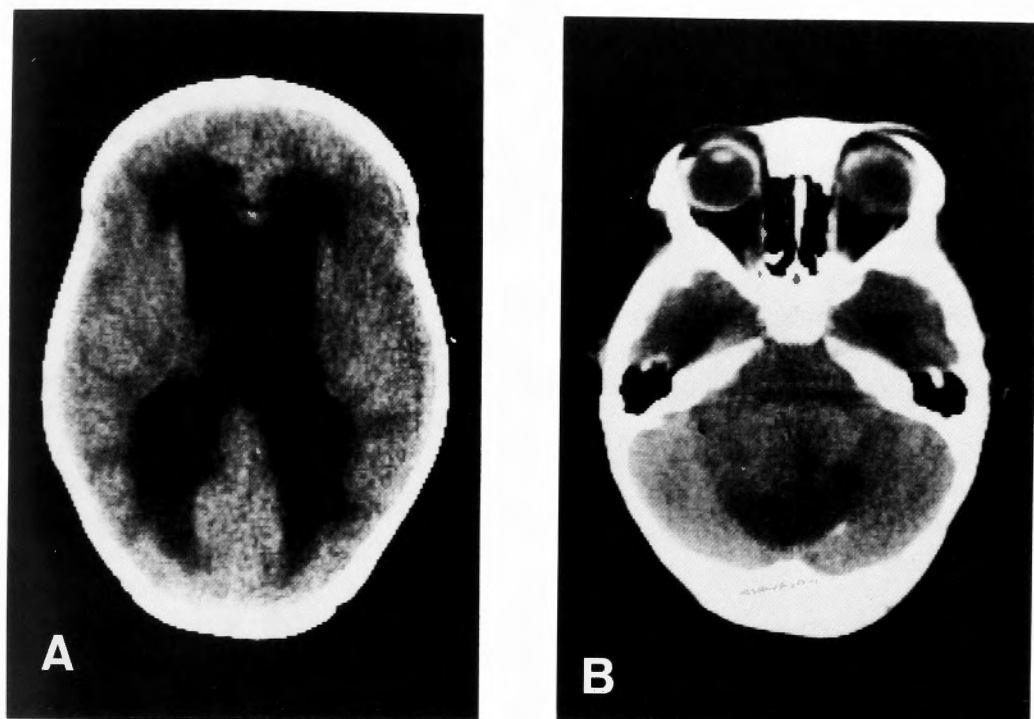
Non-contrast CT scan shows hydrocephalus (A) due to a cerebellar mass with iso- and hypodensity compared with the brain (B).
